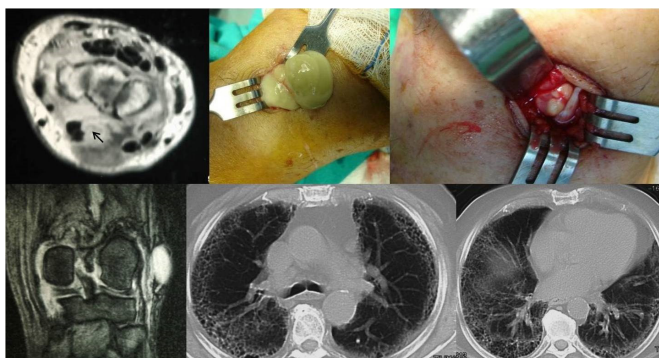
A 70-year-old man diagnosed with young-onset RA was admitted with an infected bursa over a rheumatoid nodule (arrow) on the dorsal aspect of his right wrist, which had displaced the extensor tendons. A nodule was also visible on the lateral side of his left knee. He was diagnosed with severe, aggressive RA. The infected bursa and the rheumatoid nodule of the wrist were surgically removed. Six months later, he was admitted with a respiratory infection, presenting with shortness of breath, a cough, and sputum production. High-resolution computed tomography of the chest showed multiple enlarged lymph nodes in the pretracheal, paratracheal, and aortopulmonary window regions. Thickening of the interlobular septa was also evident with a subpleural, peripheral, and basal distribution (reticulation). Interstitial subpleural emphysema cysts were also present. The 'stacked' appearance of cystic airspaces (honeycombing) confirmed severe progression of interstitial lung abnormalities.
